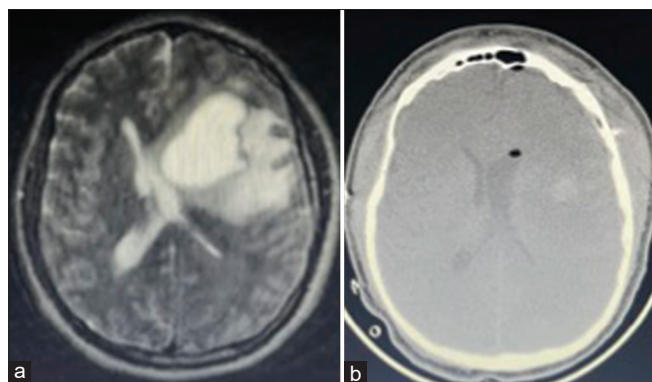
(a) T2-weighted axial magnetic resonance imaging showing a tumor within the left frontal lobe with vasogenic edema causing significant mass effect and midline shift. (b) 8-h postoperative tomography.
